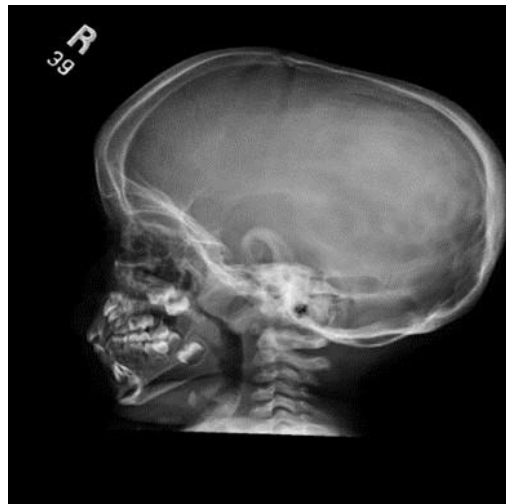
Radiograph showing the sagittal suture with elongation of the cranium in patient #7
